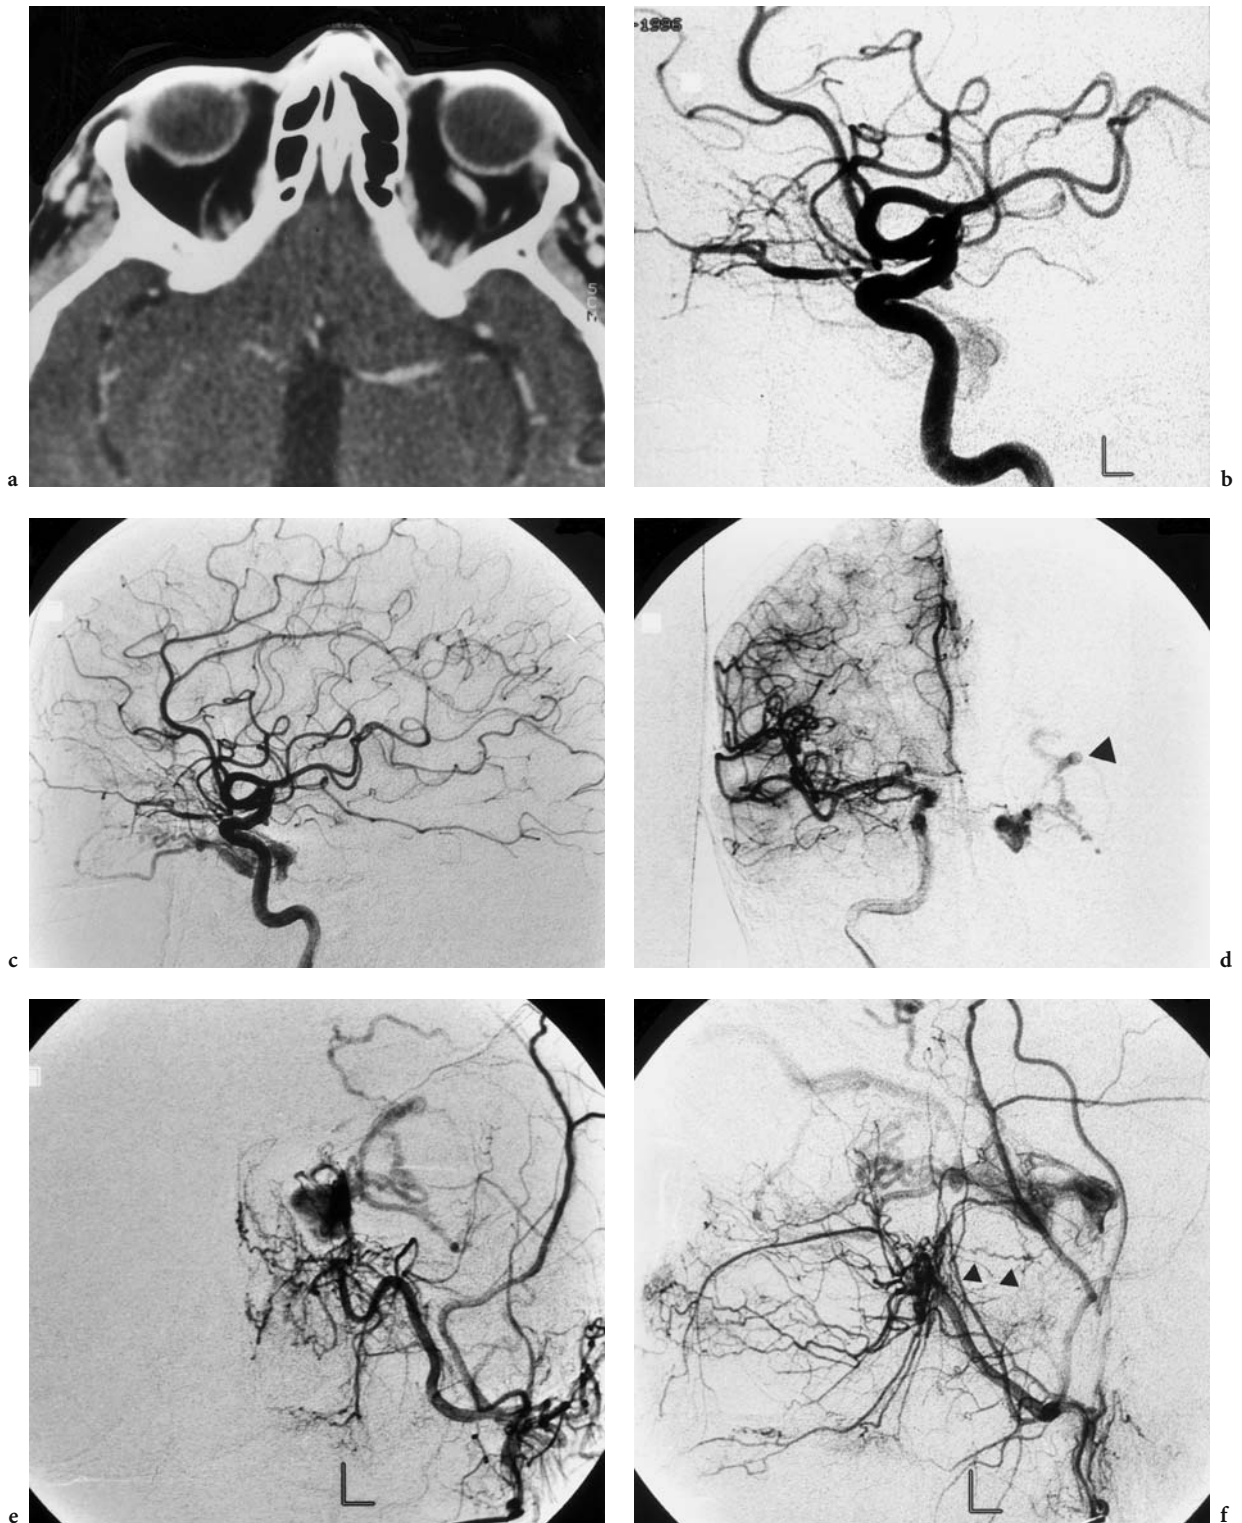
A 74-year-old woman with progressive vision loss and chemosis of the left eye. Diagnosis: carotid-cavernous sinus fistula (CCF), type B. CT: a Axial contrast-enhanced image with slight, but unequivocal enlargement of the left superior ophthalmic vein. DSA: b Lateral view of the left ICA, showing a slightly contrasted cavernous sinus. c Later phase of the lateral view of the left ICA with improved filling of the cavernous sinus. d AP view of the right ICA; comparable to the left side; small capillary-sized arteries of the inferolateral trunk can be identified and are suspected of feeding the low-flow shunt; antegrade filling of the cavernous sinus and the superior ophthalmic vein (*arrowhead*). e AP view of the left external carotid artery (ECA). f Lateral view of the left ECA with an additional shunt fed by the artery of the round foramen (*arrowheads*)
